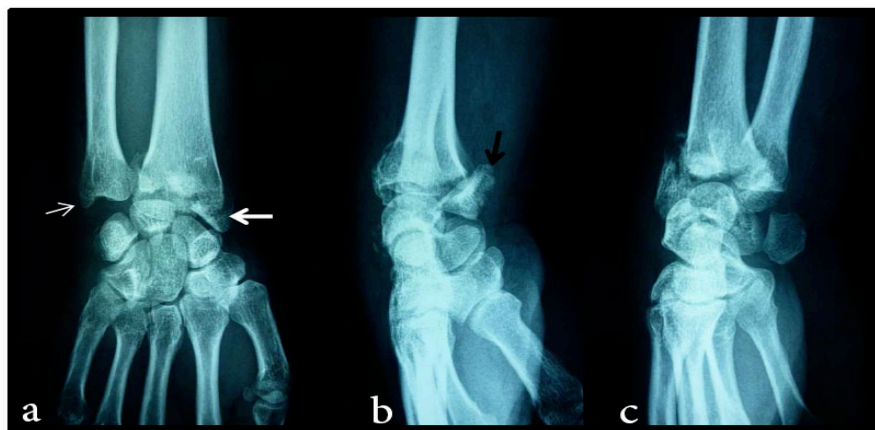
(a) Antero-posterior radiograph showing a Melone type 4 fracture of the distal radius and a displacement of the styloid process (white arrow) with fracture of the tip ulnar process (white small arrow); (b) Lateral radiograph showing 90° rotation of the lunate facet (black arrow). (c) The oblique view is not contributory.
